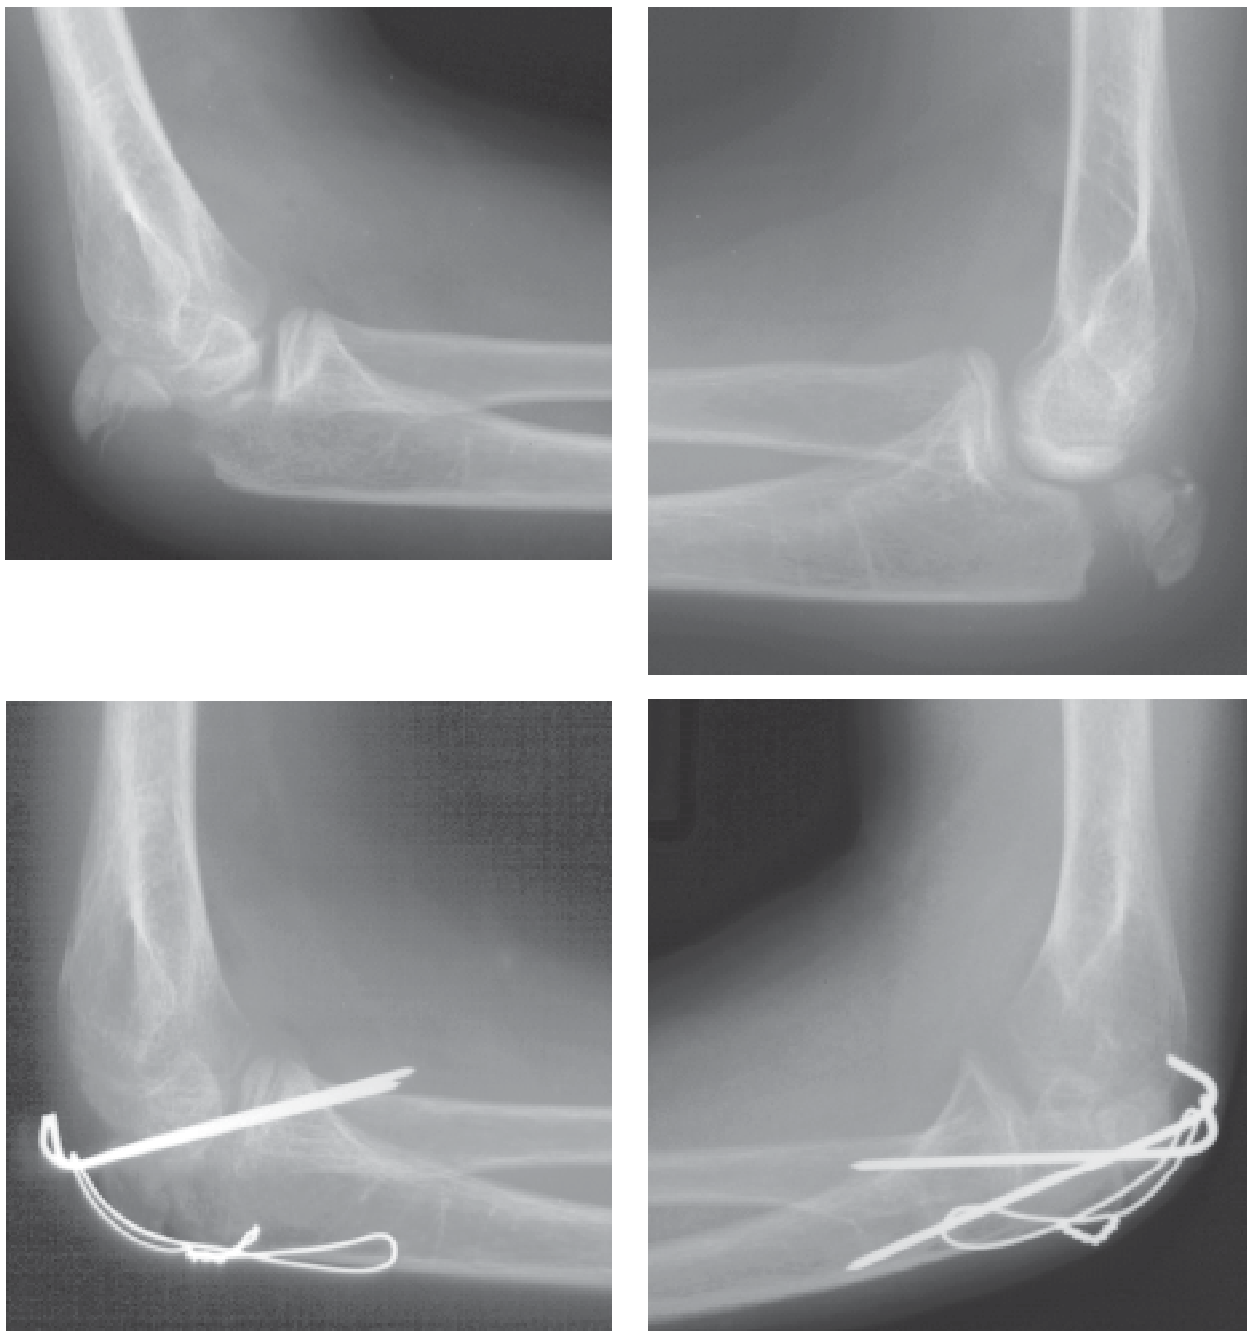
(a,b,c,d): Bilateral isolated olecranon fracture after minor trauma in a 10-year-old boy is suggestive of the osteogenesis imperfecta (a,b). Postoperative X-ray after fracture fixation with K-wires (c,d).
